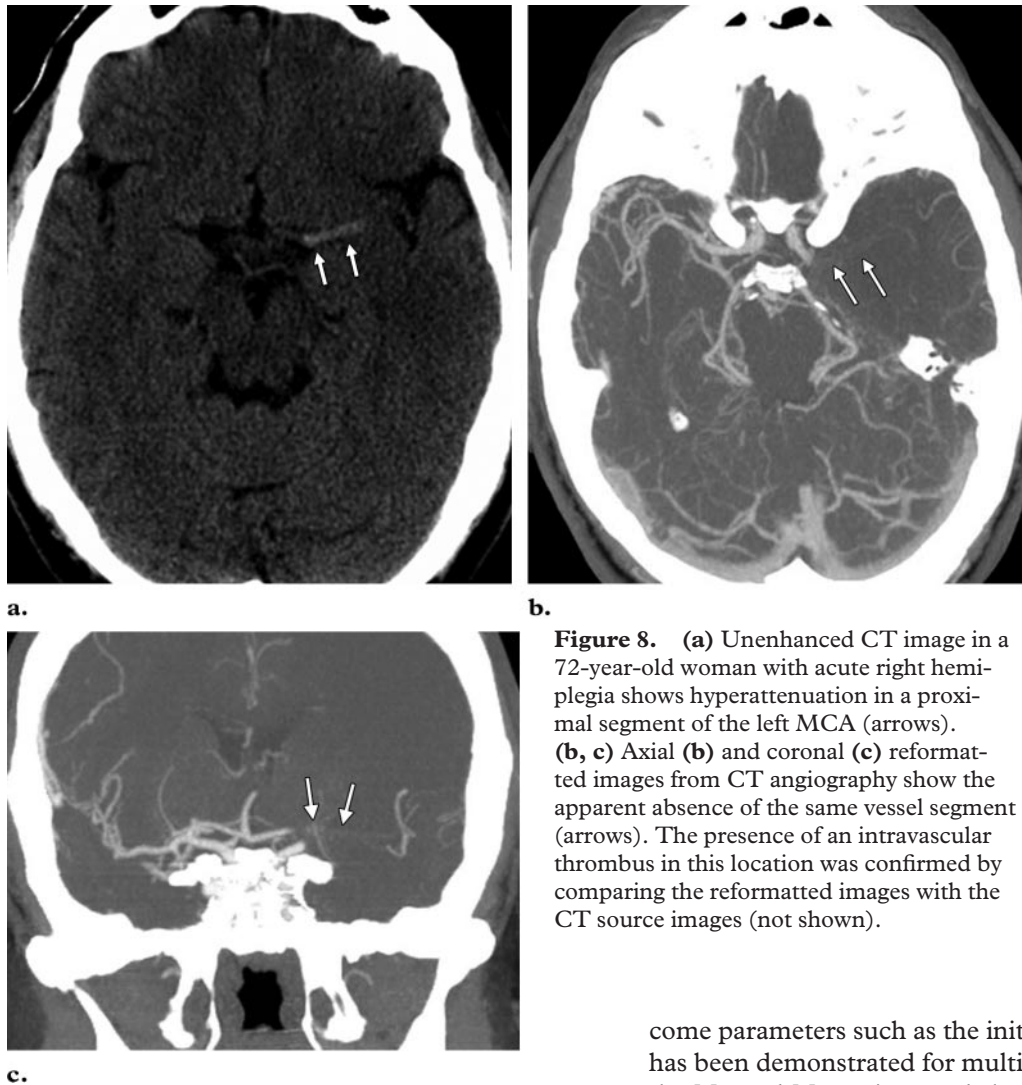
(a) Unenhanced CT image in a 72-year-old woman with acute right hemiplegia shows hyperattenuation in a proximal segment of the left MCA (arrows). (b, c) Axial (b) and coronal (c) reformatted images from CT angiography show the apparent absence of the same vessel segment (arrows). The presence of an intravascular thrombus in this location was confirmed by comparing the reformatted images with the CT source images (not shown).
